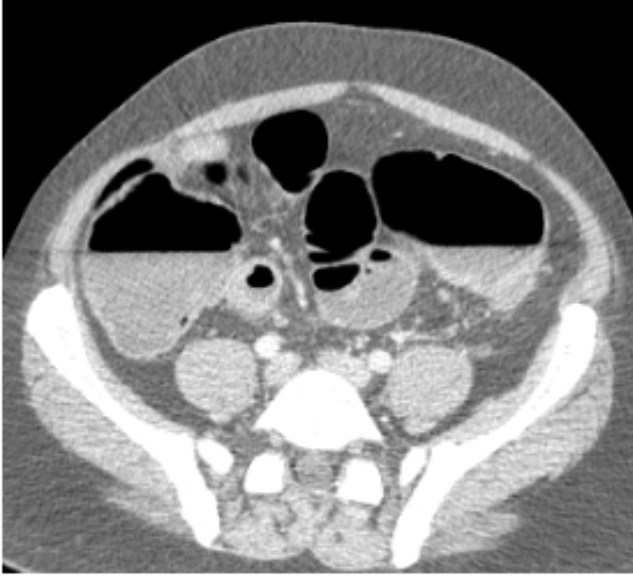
CT shows dilated large bowel (more than 5.5 cm) and the presence of air-fluid levels in this patient with ulcerative colitis suggesting toxic megacolon.
